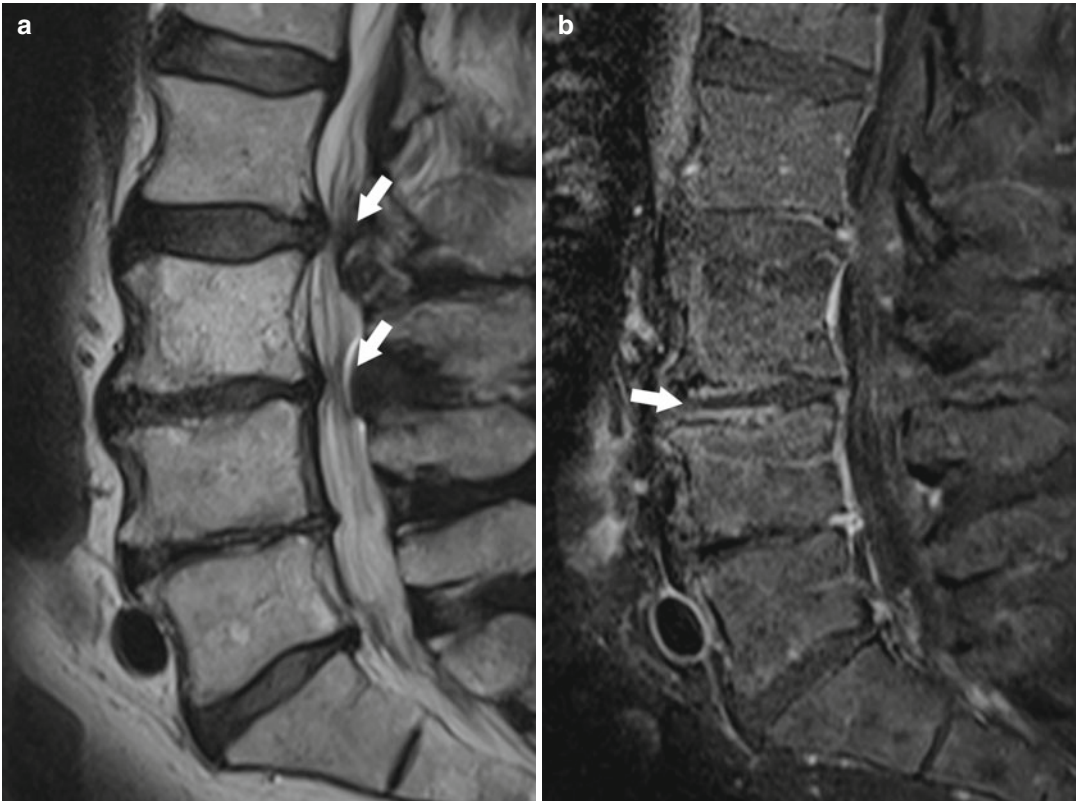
Canal stenosis (*arrows*) secondary to posterior disk bulge and posterior facet hypertrophy on sagittal T2w MR image (a); degenerative disk demonstrates linear
